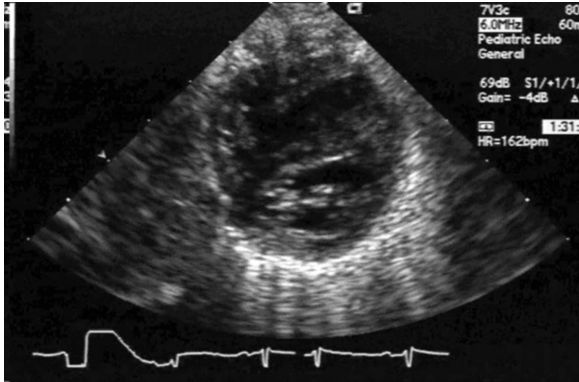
Echocardiographic parasternal short axis view, demonstrating the pancaking effect of the right ventricle (RV) on the left ventricle (LV).
